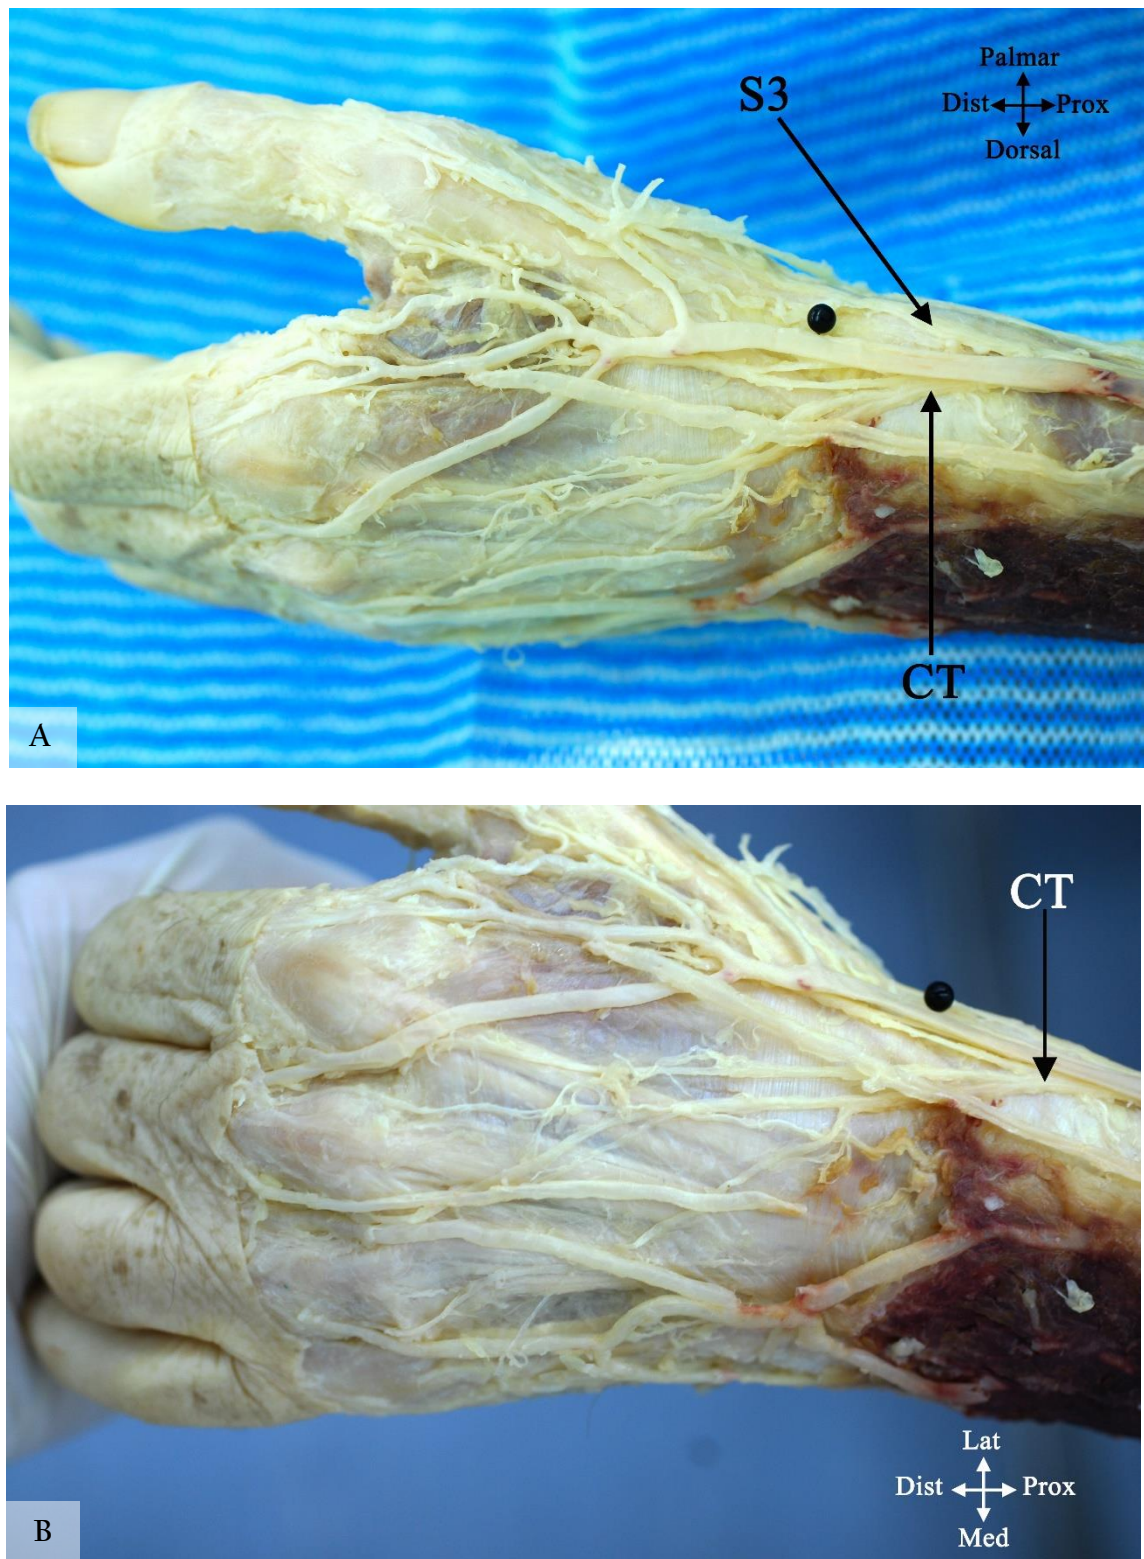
Branching pattern of the superficial branch of the radial nerve (SBRN) Type VIB. (A) Lateral view of Type VIB. (B) Dorsal view of type VIB. CT, common trunk; pins indicate the radial styloid process. Prox, proximal; Dist, distal; Lat, lateral; Med, medial; Palmar, palmar surface; Dorsal, dorsal surface.
